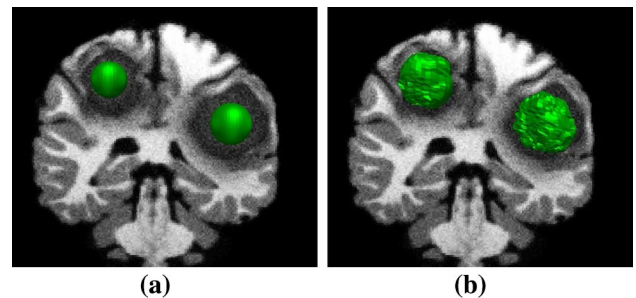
MRI tumor segmentation. a Experiment setup. One e_M for each tumor (*green*). b DMA result (color figure online)
